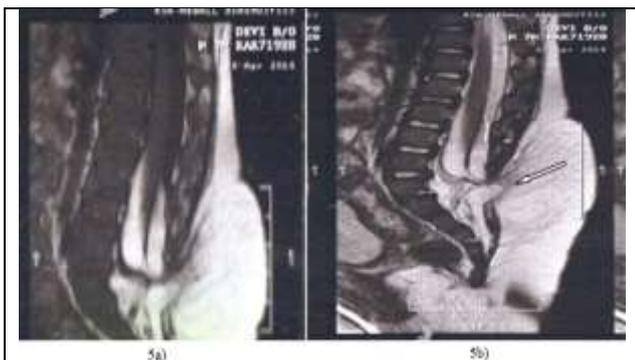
Sagittal T1-weighted and 5b) T2-Weighted MR Demonstrates Lumbosacral Lipomyelomeningocele. Dorsal Extent of Neural Placode is Seen Clearly (Arrow)
